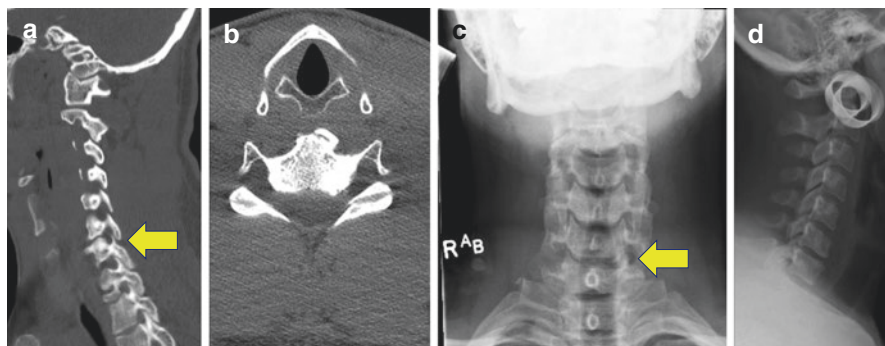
This is a case presentation of a 26-year-old professional body builder. He presented to our clinic with complaints of left arm pain and triceps weakness that had progressed over several months. He did demonstrate weakness in his left triceps compared to his right side. He had received two prior ESIs which temporarily provided relieve. Panel (a) shows a parasagittal CT scan showing the left foramen. The arrow points to the left neuroforamen and demonstrates a bony osteophyte extending from the superior articulating process causing stenosis. Panel (b) shows a CT scan axial image of the C6-7 neuroforamen. The left neuroforamen is stenotic compared to the contralateral side. MRI (not shown) again demonstrated neuroforaminal stenosis with a disc herniation. We had a discussion with the patient and elected to move forward with a left-sided C6-7 laminoforaminotomy. Panel (c) demonstrates an AP radiograph at 6 months post-op. The yellow area shows the decompressed foramen. Panel (d) is a lateral radiograph at 6 months post-op demonstrating maintained lordosis with minimal spondylosis. The patient was able to return to weight lifting at 3 months post-op
